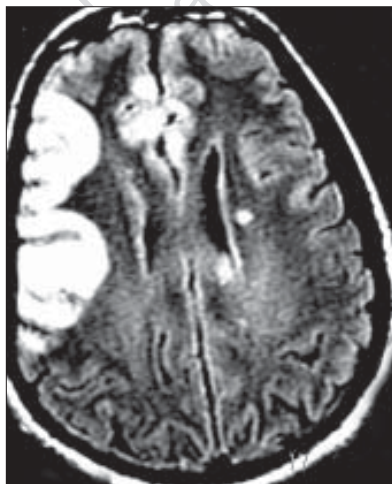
Brain fluid attenuated inversion recovery MR image showing a cortical infarct in right middle cerebral artery territory, a hyperintense signal in the territory of the anterior cerebral artery along with a lacunar infarct in left periventricular white matter
